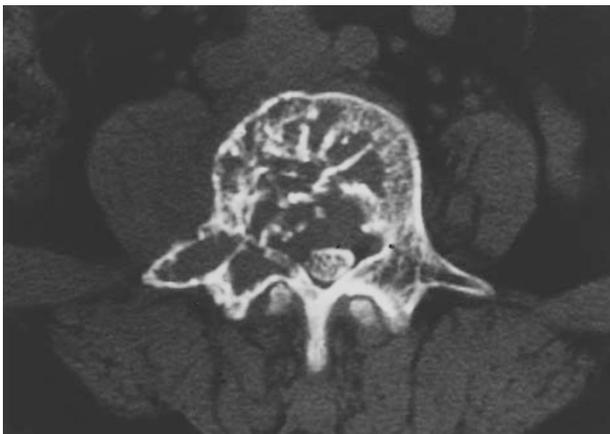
Computed tomography scan of case 2 showing tumorous involvement of the vertebral body, facet joint and the lamina at L4 level
